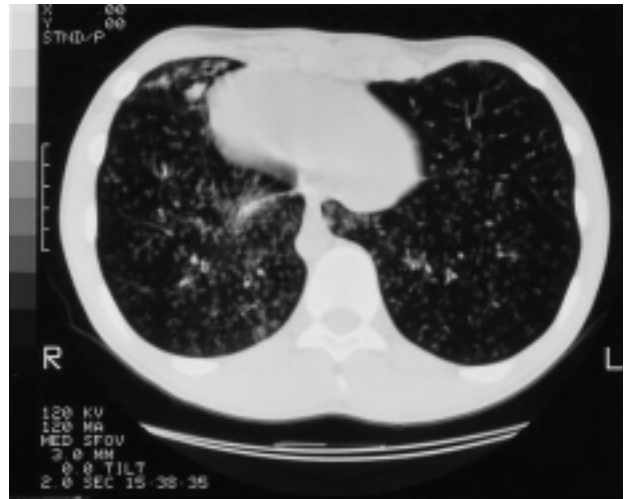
Chest computed tomography scan showing dextrocardia, bronchiolectasis and diffuse centrilobular small nodules throughout both lungs (patient 7).
